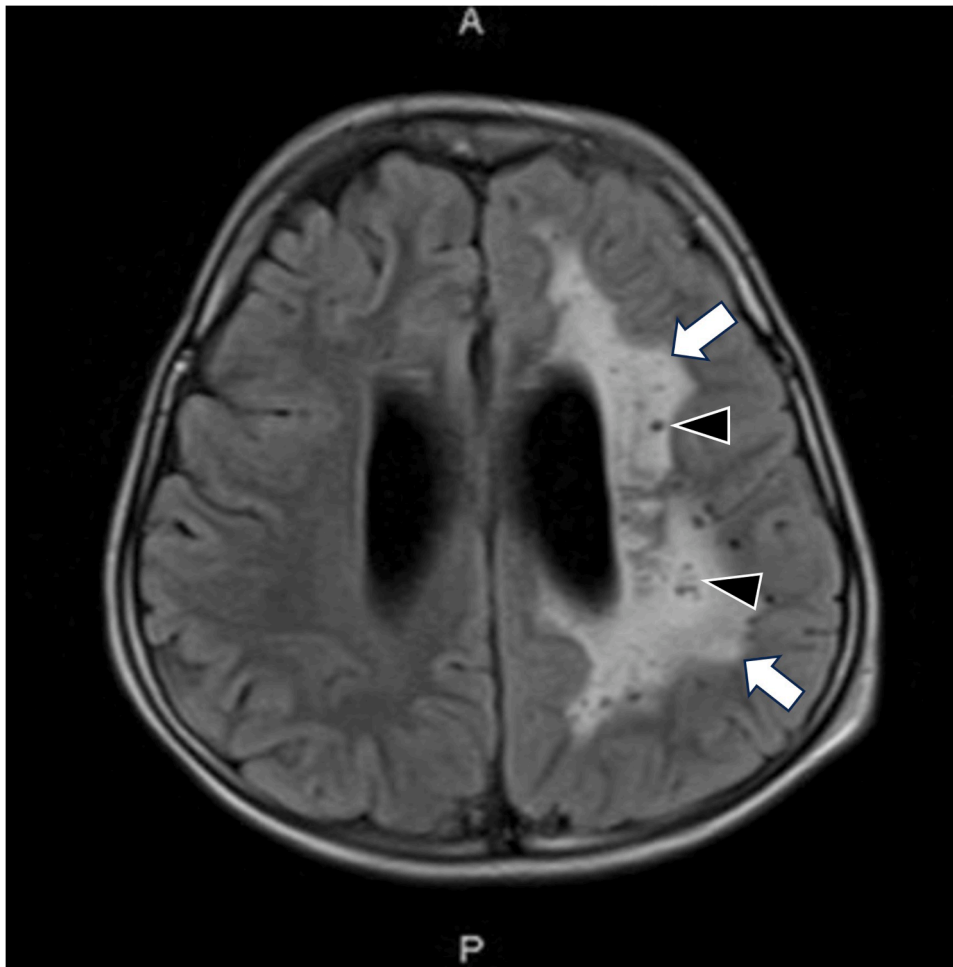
MRI Findings in hypomelanosis of Ito.
